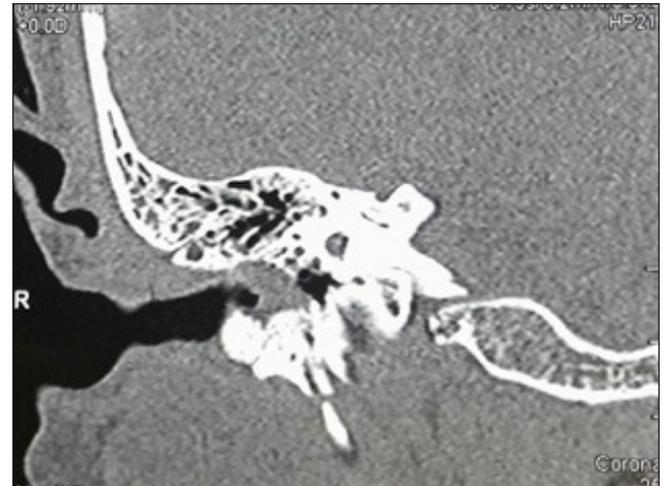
coronal view of high resolution CT scan of the petrous temporal bone: showing an enlarged right CAE with a soft tissue filling the entire duct with a balloon appearance
